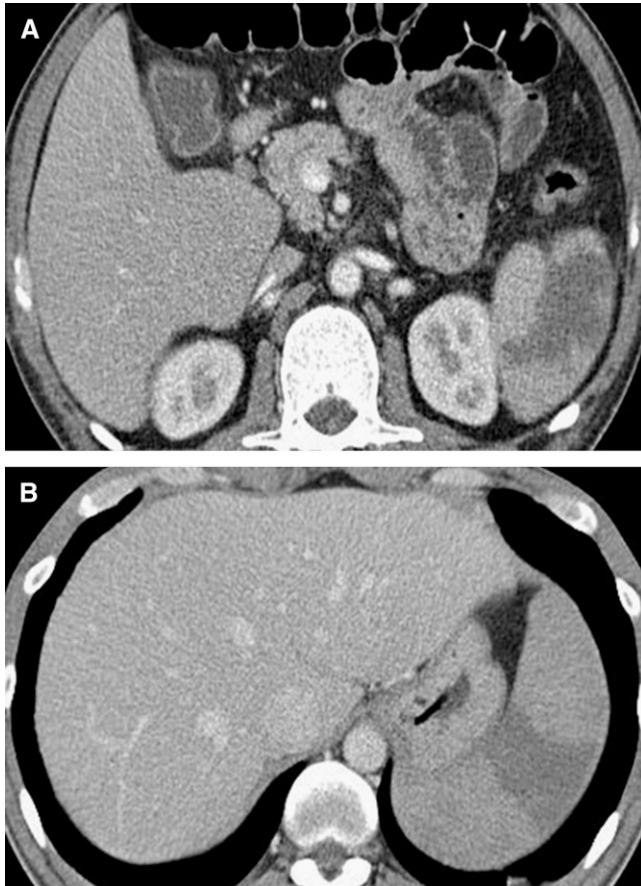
Contrast-enhanced computed tomography of two patients, case 1 (A) and case 2 (B), showing low attenuation density in the spleen.
